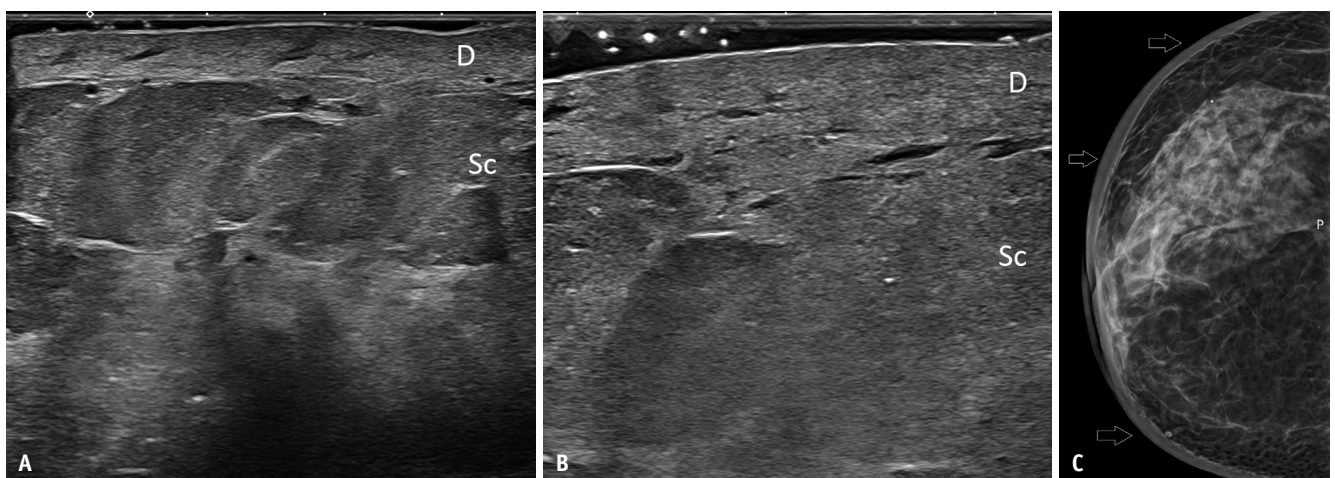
Post-radiation therapy cutaneous fibrosis. A: US scan at 15 MHz. The dermis is thick and echoic. The subcutis is hypoechoic. B: US scan at 24 MHz. The dermis is thick and echoic. The subcutis is hypoechoic. C: The two layers cannot be distinguished from each other. Cranio-caudal mammographic view in the same patient. Diffuse skin thickening (arrows). US = ultrasound, D = dermis, Sc = subcutis
